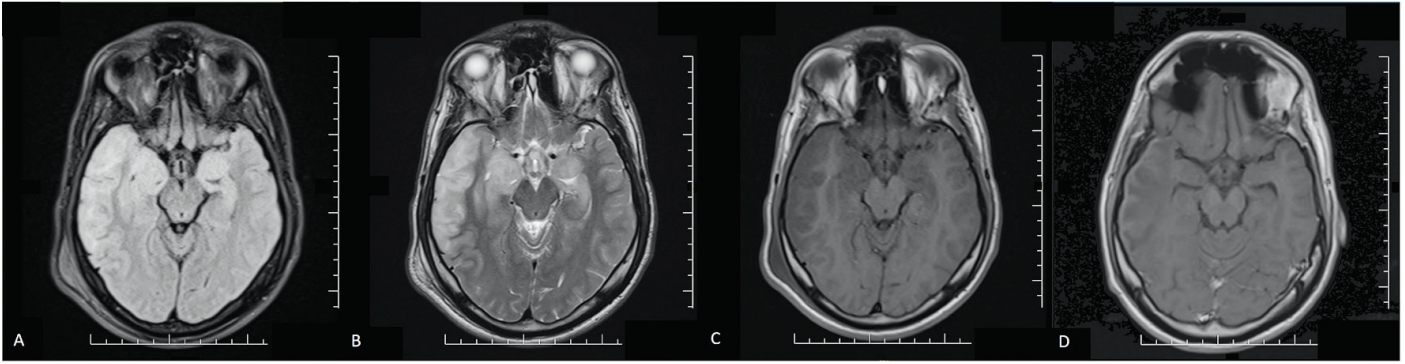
A-D) MRI findings of patient
